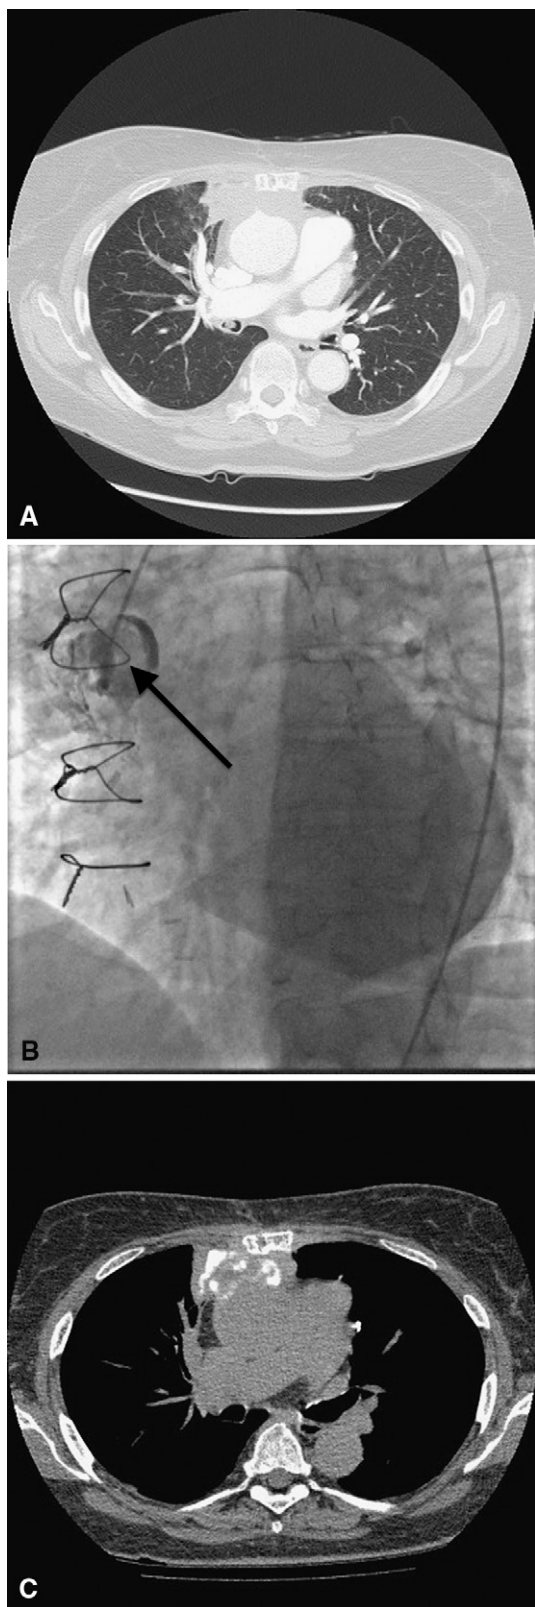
A, Contrast chest computed tomography demonstrating filling defect in the bronchus intermedius consistent with hemorrhage within airway, retrosternal fluid collection, and opacification of the right upper
